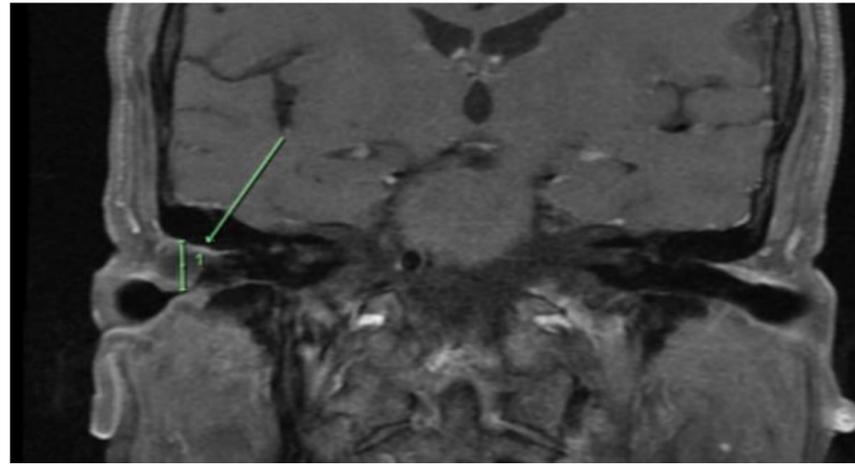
Magnetic resonance imaging demonstrating a 1.3cm lesion in relation to the peripheral portion of the right external auditory canal
